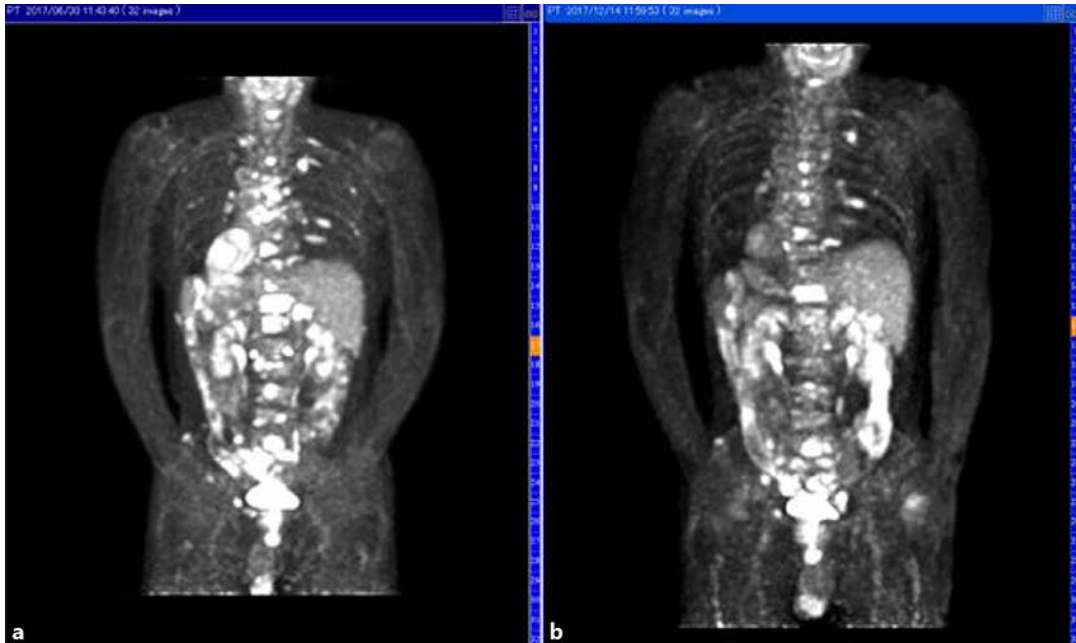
18F-FDG-PET. Initial diagnosis (a). After 4 cycles of modified THP-COP treatment (b), accumulation in the lymph node disappeared and standardized uptake value max in Th 12 decreased from 7.2 to 5.4.
